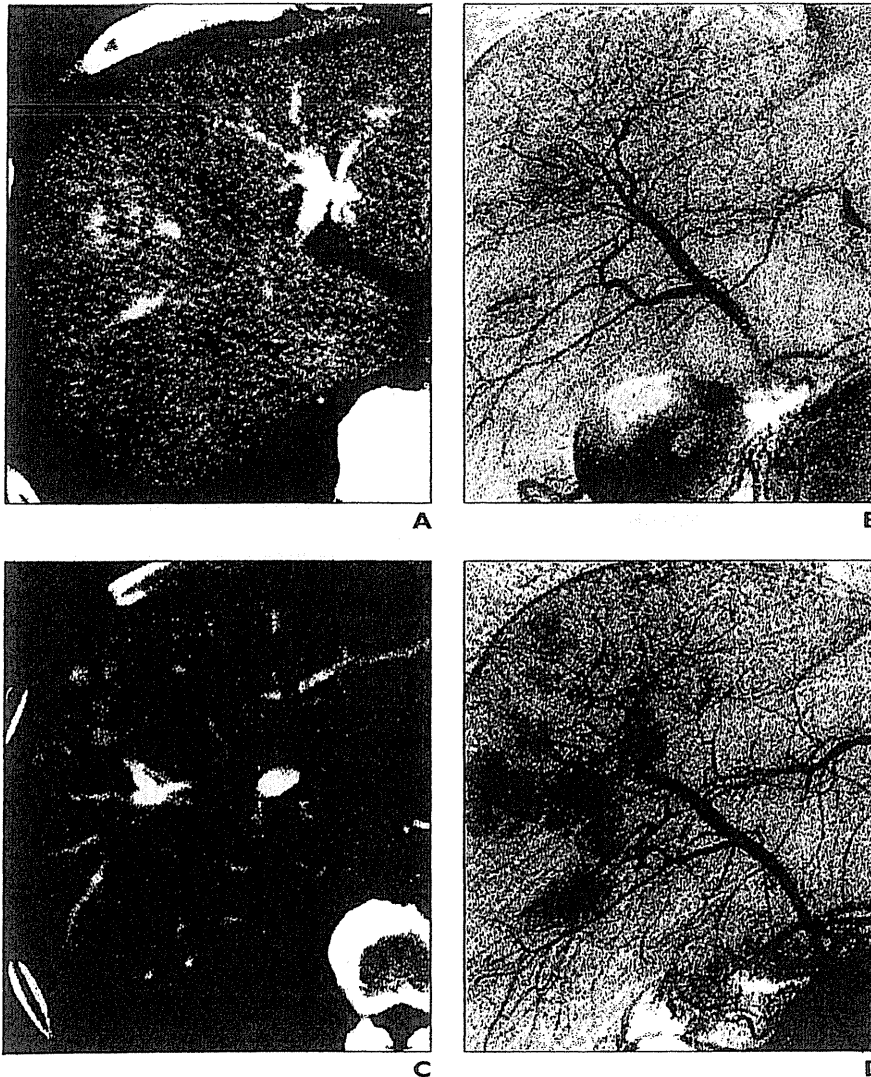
83-year-old man with hepatocellular carcinoma (case 7 in Table 3). A, Pretreatment dynamic CT (arterial phase) image. Tumor shows heterogeneous enhancement pattern with irregular ringlike structures—that is, type 4 enhancement pattern. B, Pretreatment digital subtraction angiography (DSA) image shows single hypervascular nodule, so radiofrequency ablation (RFA) was performed. C, Dynamic CT study (arterial phase) image obtained at time of recurrence after RFA (1.5 years after treatment) shows multiple hepatic tumors are observed around previously ablated area. D, DSA image at time of recurrence shows multiple hepatic tumors are observed around original tumor.
